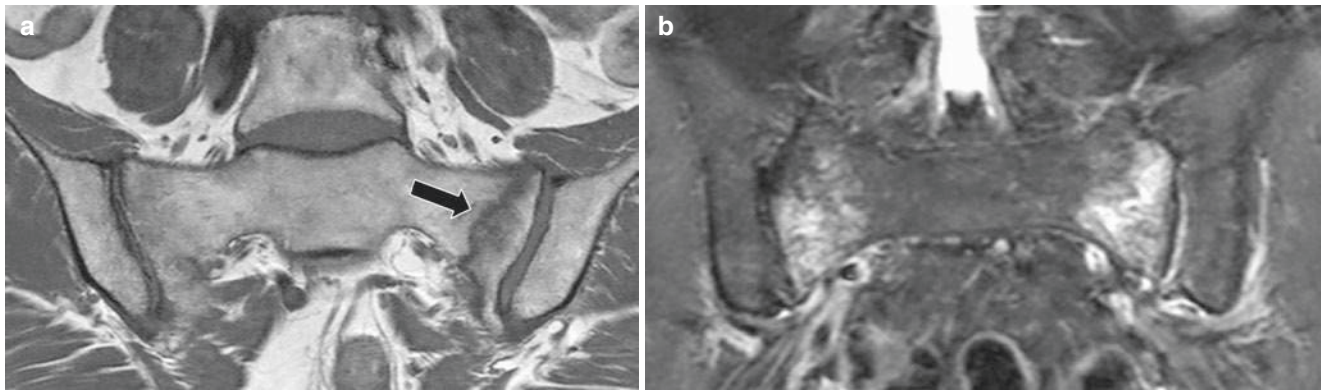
Bilateral ISF of the sacrum. (a) A coronal T1-weighted image of the sacrum demonstrates a low signal intensity line (*arrow*) in left sacrum with adjacent marrow edema. (b) A coronal STIR image demonstrates bilateral extensive edema in sacrum
